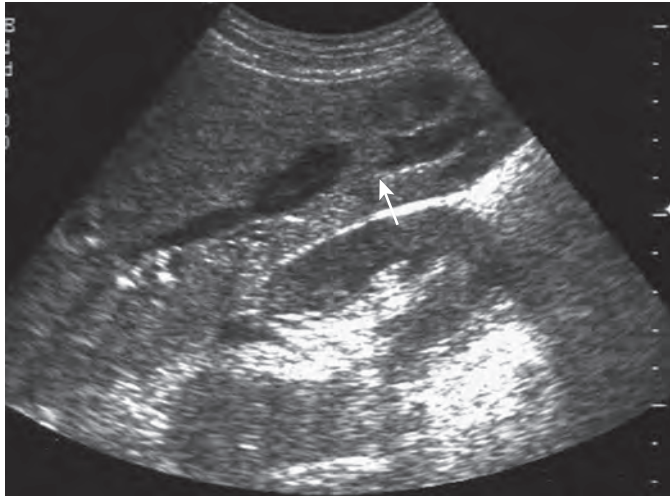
Papillary cholangiocarcinoma. Sonogram shows a papillary cholangiocarcinoma filling the dilated right intrahepatic bile duct (arrow).
